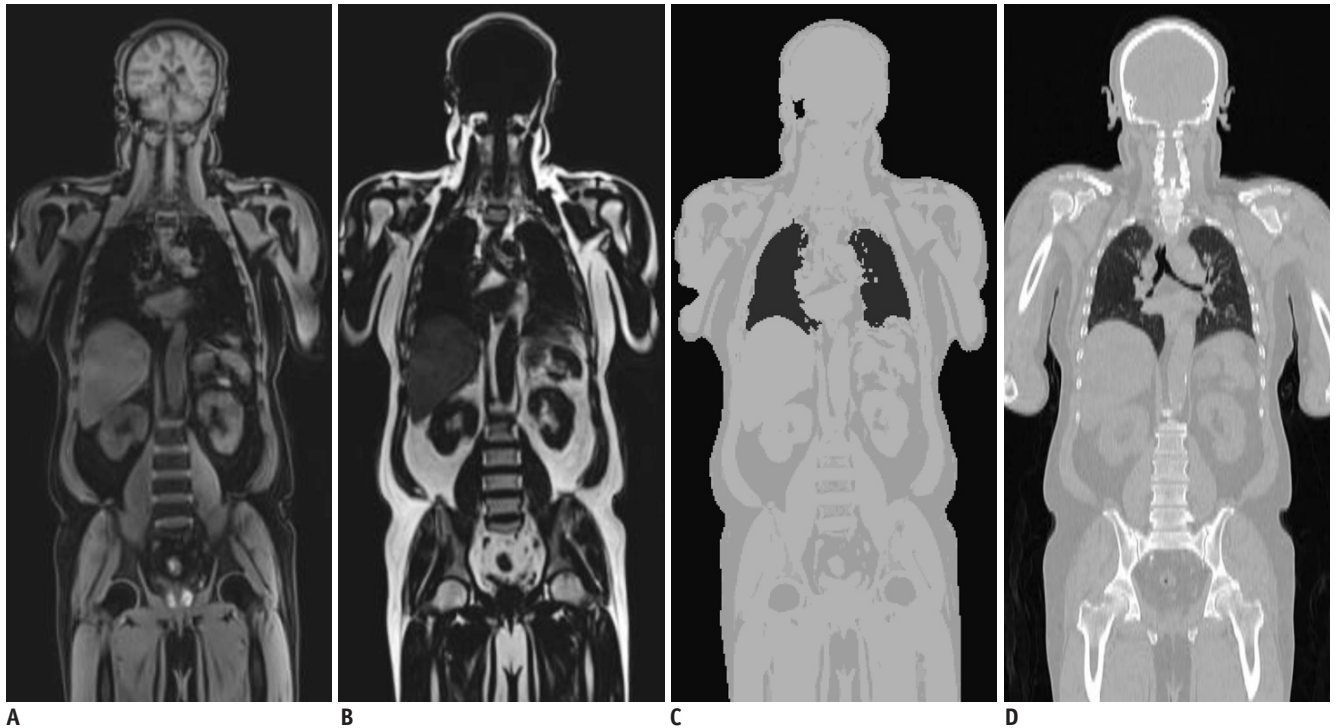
Dixon MRI-based attenuation correction.
